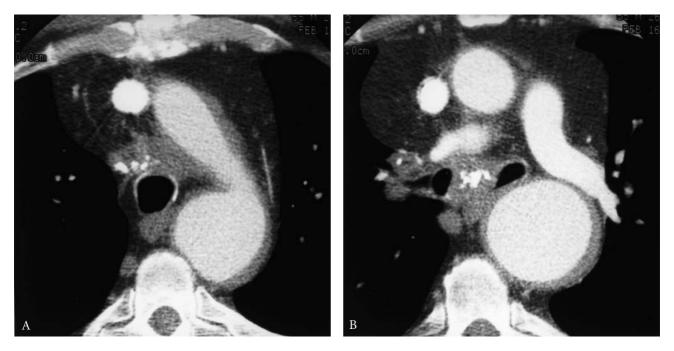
Fibrosing mediastinitis. Computed tomography scans through the distal trachea (A) and main bronchi (B) with intravenous contrast reveal narrowing and distortion of the trachea and bronchi. There is surrounding fibrosis that contains calcification.
